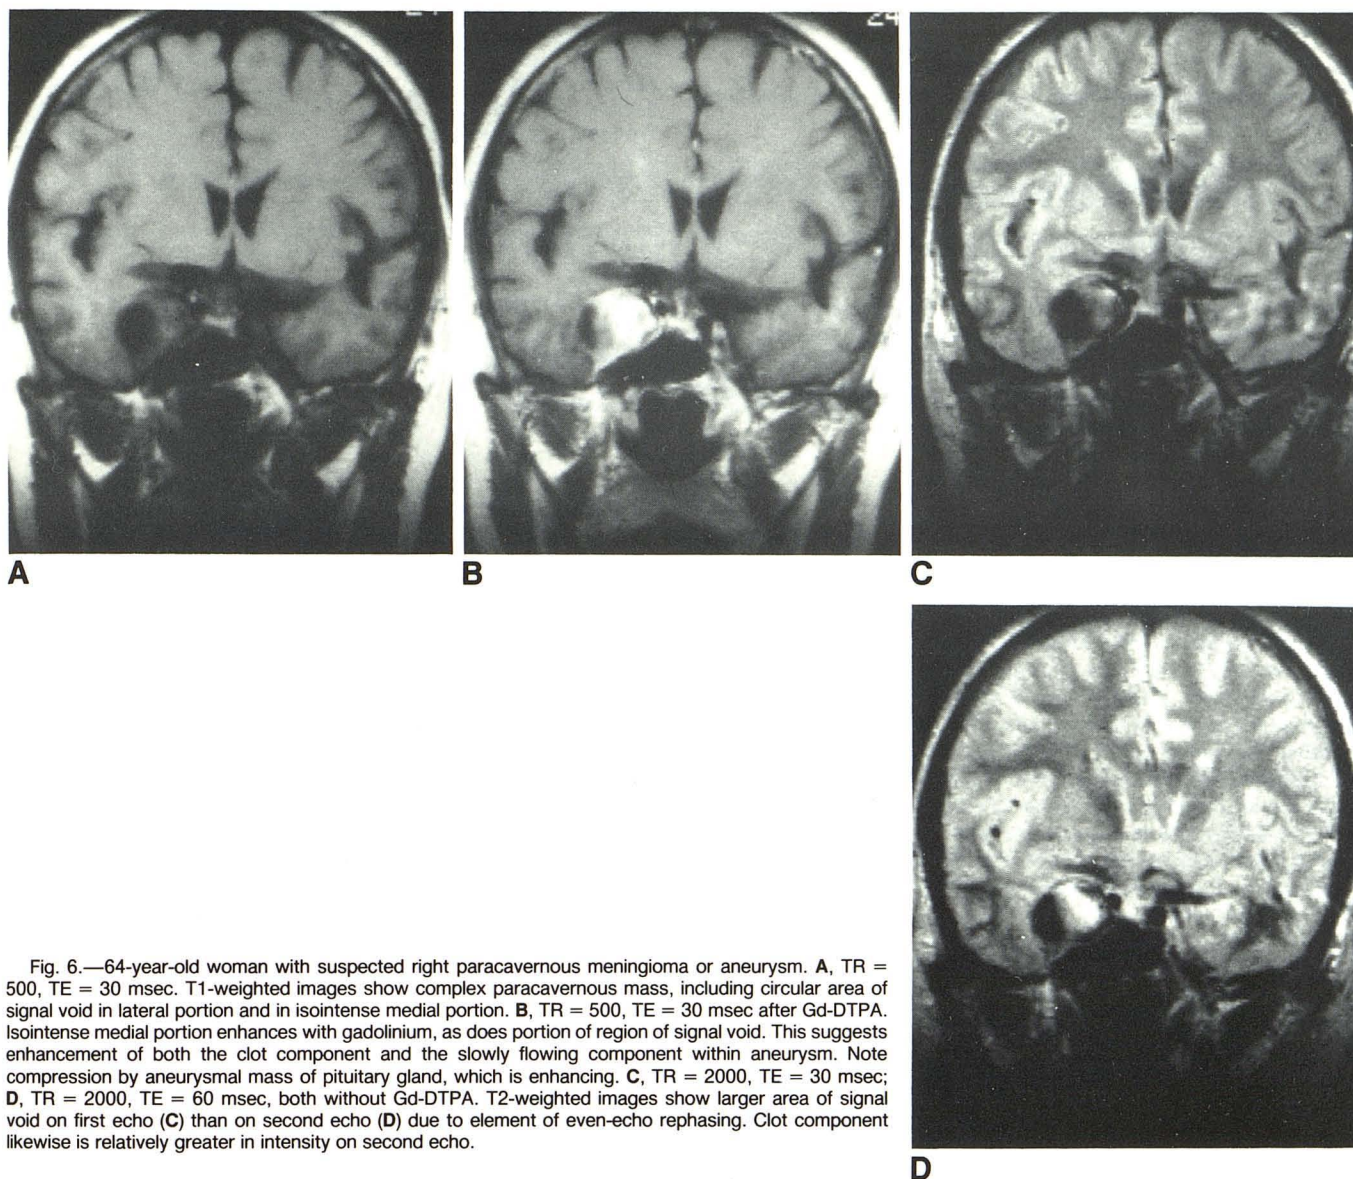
64-year-old woman with suspected right paracavernous meningioma or aneurysm. A, TR = 500, TE = 30 msec. T1-weighted images show complex paracavernous mass, including circular area of signal void in lateral portion and in isointense medial portion. B, TR = 500, TE = 30 msec after Gd-DTPA. Isointense medial portion enhances with gadolinium, as does portion of region of signal void. This suggests enhancement of both the clot component and the slowly flowing component within aneurysm. Note compression by aneurysmal mass of pituitary gland, which is enhancing. C, TR = 2000, TE = 30 msec; D, TR = 2000, TE = 60 msec, both without Gd-DTPA. T2-weighted images show larger area of signal void on first echo (C) than on second echo (D) due to element of even-echo rephasing. Clot component likewise is relatively greater in intensity on second echo.
